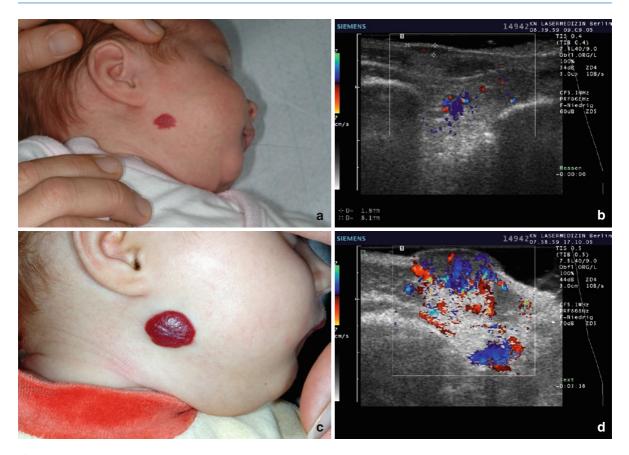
(a) Hemangioma assumed to be only superficial. (b) In color-coded duplex sonography (CCDS) hyposonic swelling of the skin; notice the faint hypersonic modification of the subcutaneous region with some small color coded vessels:
